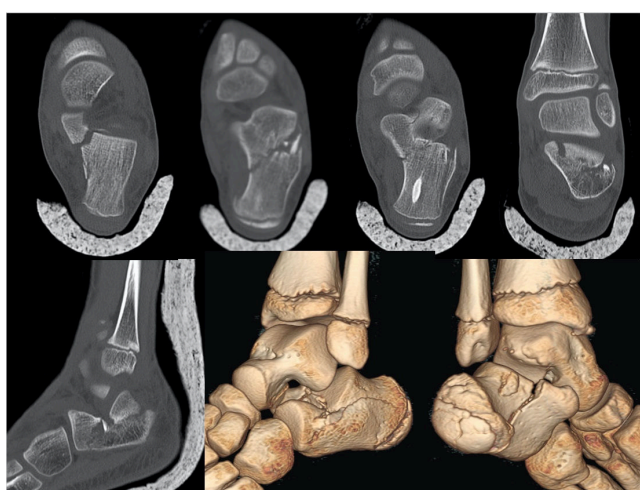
CT showing a complex fracture of the calcaneus with involvement of the subtalar joint, crushing and sagging of the articular surface of the thalamus, fracture of the sustentaculum tali and the body of the calcaneus with multiple fragments (type IV of the Sanders classification).
